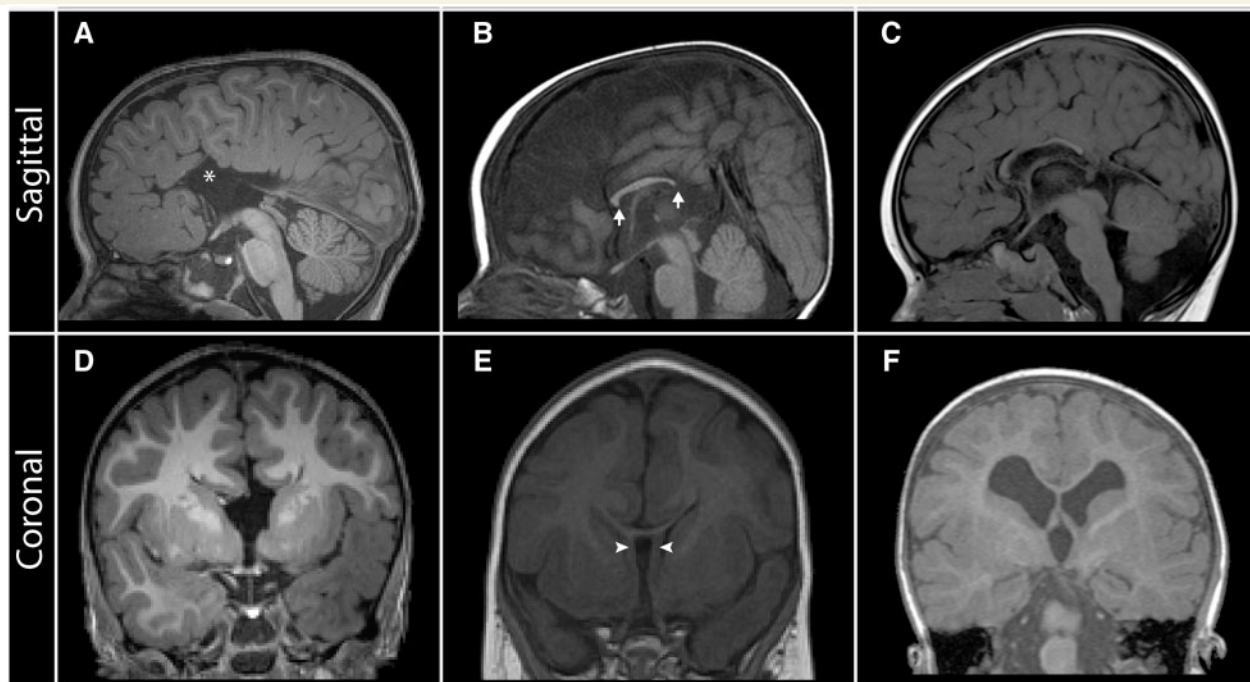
Neuroanatomical features revealed by T₁-weighted midsagittal and coronal MRI in patients with corpus callosum abnormalities. (A and D) Patient with complete ACC associated with dorsal expansion of the third ventricle (asterisk), absence of the cingulate gyrus and sulcus, and absence of the septum pellucidum. (B and E) Patient with partial ACC; the splenium is absent and the rostrum is not fully formed (arrows). In addition, the leaves of the septum pellucidum are unfused (E; arrowheads). (C and F) Patient with hypoplasia of the corpus callosum. All segments are present but are diffusely thinned; there is also markedly reduced cerebral white matter volume (F).
